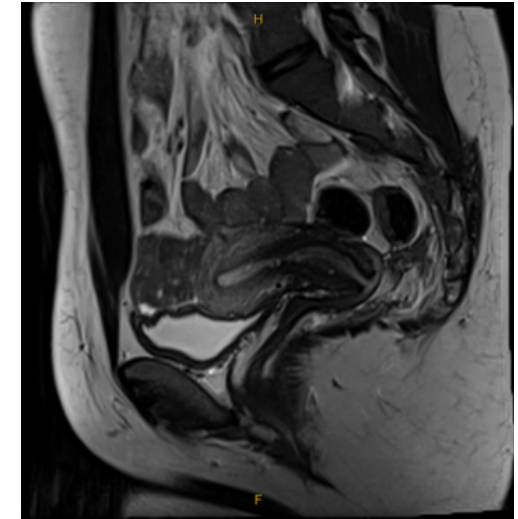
4 month surveillance MRI after cessation of COCP
